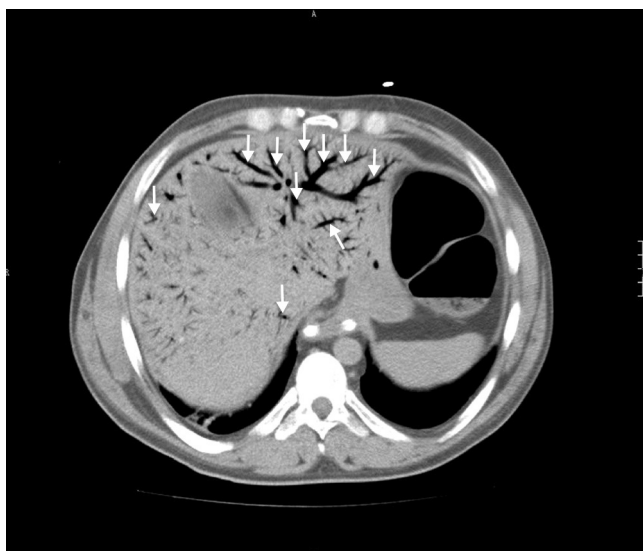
Abdominal contrast-enhanced computed tomography showing large areas of hepatic portal venous gas – *aerportia* (white arrows).
